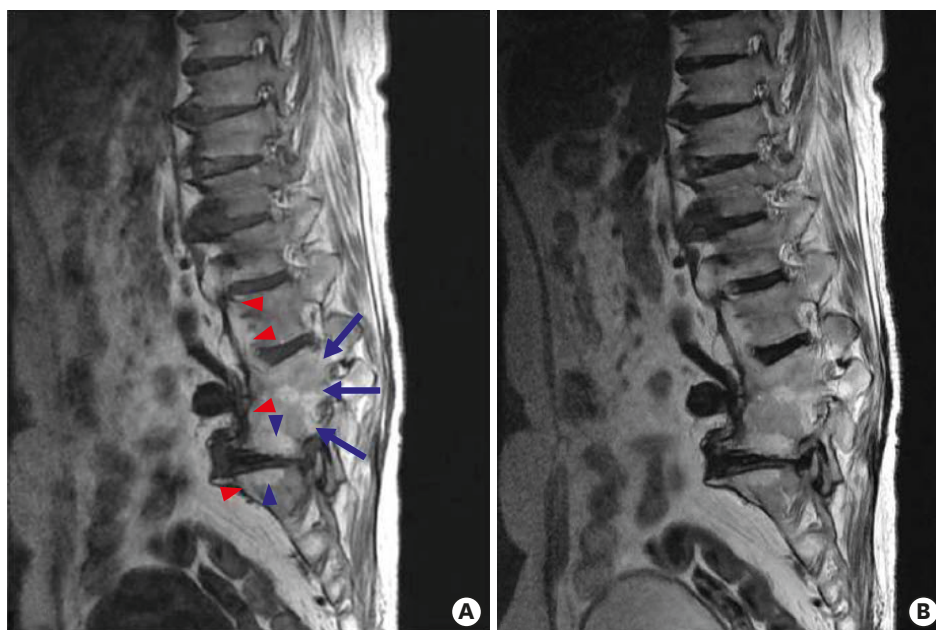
T1- and T2-weighted sagittal magnetic resonance images (A & B) reveal severe foraminal stenosis and complete fusion of vertebral bodies. Each of the 3 pedicles is observed (arrows) and the “Andersson lesion” is visible at the antero-inferior portion at L5 and the antero-superior portion at S1 (blue arrowheads). “Shiny corner sign” is visible at anterior vertebral corners as high signal intensity (red arrowheads).
